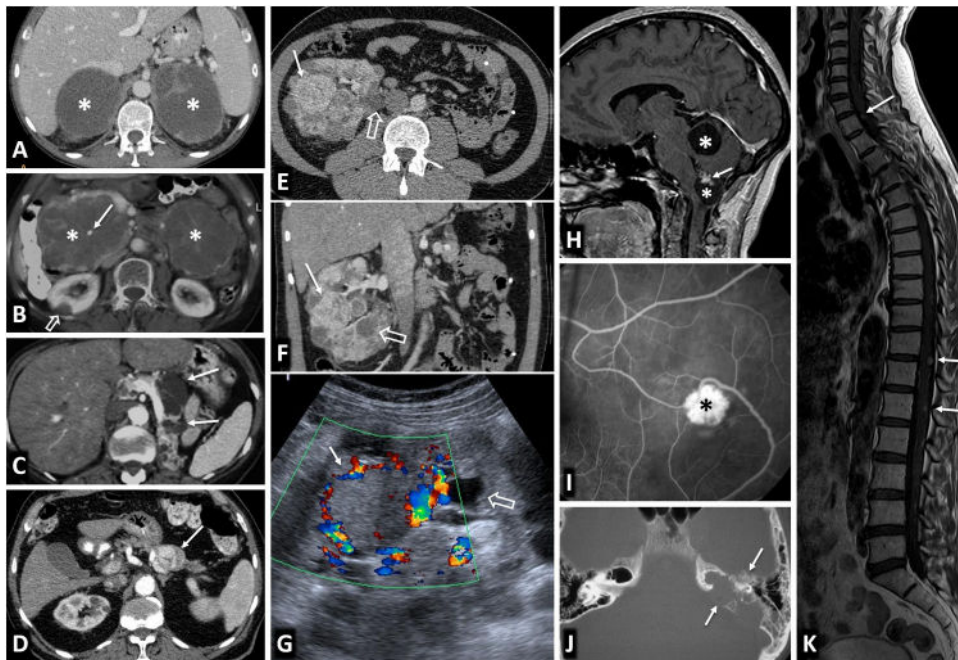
Von Hippel-Lindau syndrome. Findings in different patients. A) Bilateral adrenal pheochromocytomas in a young male. CT: large well-defined masses in both adrenal glands (*), with predominant cystic areas. B) Multiple pancreatic serous cystadenomas in a young female. CT: two large multicystic pancreatic masses (*) can be seen, with radiating septa and, on the right, a small central calcification (arrow). A right cortical renal cyst can also be seen (hollow arrow). C) Multiple pancreatic cysts. CT: cysts of various sizes (arrows) in the body and tail of a repositioned pancreas after left nephrectomy for multiple clear cell renal carcinomas. D) Pancreatic neuroendocrine tumour. CT: small nodular lesion (arrow) with intense enhancement in the arterial phase, in the body of the pancreas. Small renal cysts can also be seen. E, F [CT], and G [Doppler ultrasound]) Multiple clear cell carcinomas (arrows) and cortical cysts (hollow arrows) in the single right kidney of a young male who has already had a left nephrectomy. H) Two cerebellar haemangioblastomas. Sagittal T1 MRI with Gd: cerebellar cystic lesions (*), with a solid nodule with heterogeneous enhancement in the lower one (arrow). I) Retinal angioma. Retinal fluorescein angiogram. Hyperfluorescent lesion (*) with a prominent arterial supply. J) Tumour of the endolymphatic sac. CT: lytic lesion (arrows) with its epicentre in the posterior petrous crest in the region of the vestibular aqueduct, with some intratumoral bone spicules. K) Multiple spinal haemangioblastomas. Sagittal, T1-weighted, Gd-enhanced MRI: small foci of intramedullary enhancement (arrows).
